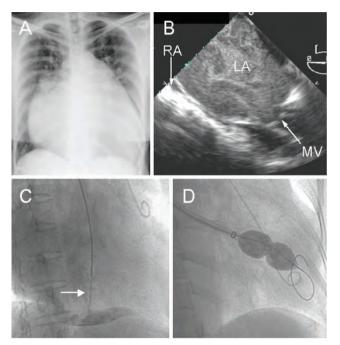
A 54-year-old lady presented with severe rheumatic mitral valve stenosis, atrial fibrillation and class III NYHA dyspnea. Chest X-ray (Panel A) showed gross cardiac enlargement (91% cardio-thoracic ratio). Transoesophageal echocardiography (Panel B) revealed a giant (95 x 100 mm) left atrium (LA) with spontaneous contrast within, slit-like right atrium (RA), and severely stenosed but pliable mitral valve (MV). The marked cardiac anatomic distortion predicted significant technical difficulty in performing conventional transfemoral mitral balloon valvuloplasty; hence a transjugular approach was used electively. The rightward bulging atrial septum was punctured (Panel C) midway between the ascending aorta (with pigtail catheter within) and the thoracic spine, in right anterior oblique view; contrast injection (arrow) through the transseptal needle delineated the left atrial floor and confirmed left atrial entry. Mitral valvuloplasty was performed using a 26mm cylindrical balloon that was introduced through an angled 14F left atrial sheath over a 0.035" guidewire (Panel D); orientation of the sheath, balloon and guidewire in a straight line, co-axial with the mitral valve, facilitated the procedure; the mid-balloon waist produced by the stenotic mitral valve was abolished. Mitral valve area increased from 0.6 cm2 to 2.3 cm2, though mitral regurgitation increased from trivial to moderate.
